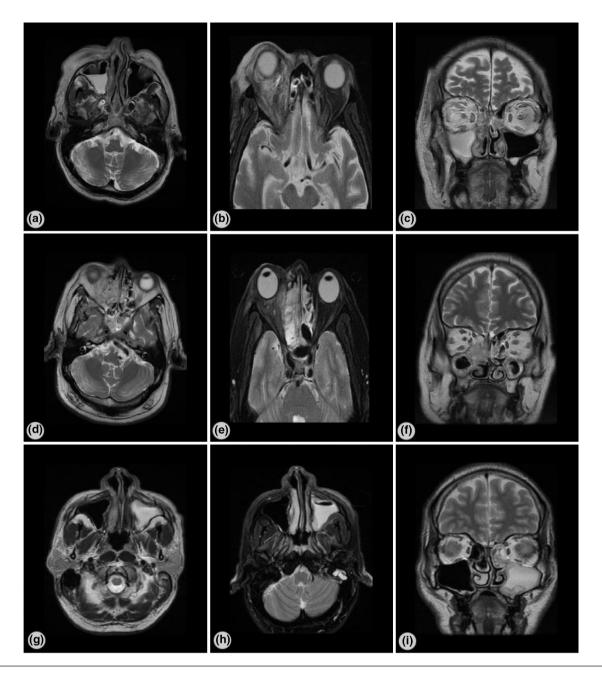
MRI brain and orbit of cases 1, 2 and 3. Case 1: [1A,1C] Axial and coronal T2W MRI showing mucosal thickening in right maxillary and bilateral ethmoidal sinuses. [1B] T2 fat sat axial MRI showing inflammatory changes of right orbital soft tissue extending to orbital apex, pre-septal/peri-orbital region with proptosis of right globe suggestive of right maxillary and ethmoidal sinusitis with orbital extension. Case 2: [1D,1F] Axial and coronal T2W MRI showing hetero intense mucosal thickening in bilateral ethmoid, maxillary and sphenoid sinuses. [1E] T2 fat sat axial MRI showing mild right eye proptosis with right orbital soft tissue inflammatory changes- suggestive of orbital extension. Case 3: [1G,1I] Axial and coronal T2W MRI showing mucosal thickening of maxillary and ethmoidal sinuses with complete opacification of the left maxillary sinus. [1H] T2 fat sat axial MRI showing left maxillary sinusitis with retro antral soft tissue inflammatory changes involving masticator space and pterygopalatine fossa suggestive of invasive sinusitis.
